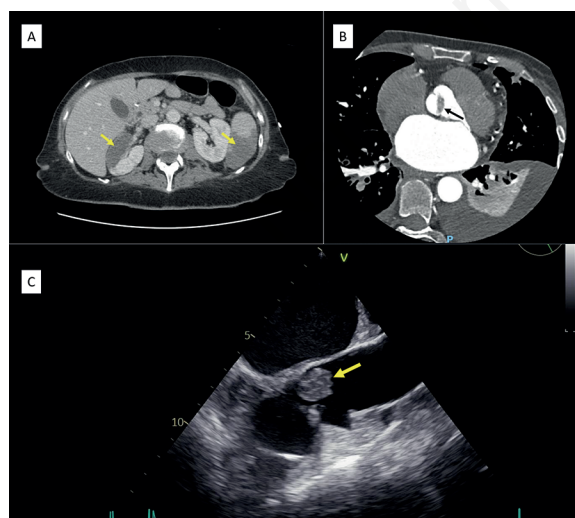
A) Abdominal computed tomography showing renal and splenic embolic lesions (arrows); B) Cardiac computed tomography showing endocarditis on both non-coronary aortic cusp and a second lesion of 4 mm at the coronary sinus (arrow); C) Transthoracic echocardiography showing an isoechoic lesion [15.5 millimeters (mm)] at the non-coronary aortic cusp (arrow).
